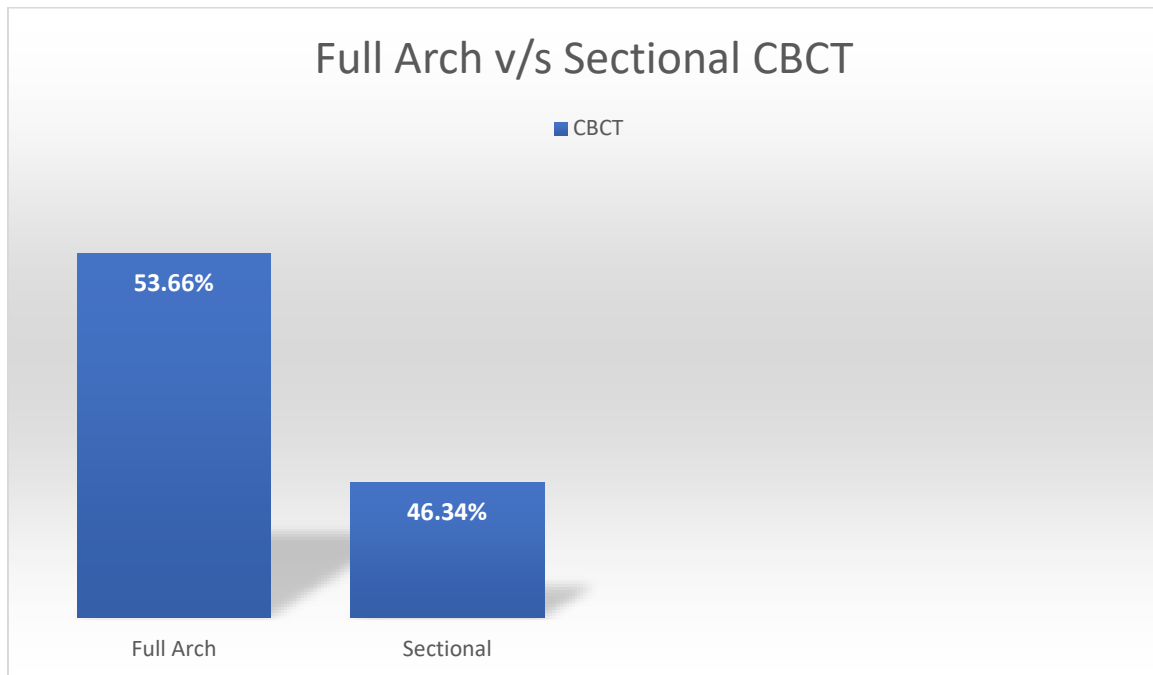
Distribution of patients based on the type of CBCT scan — Full Arch versus Sectional.
